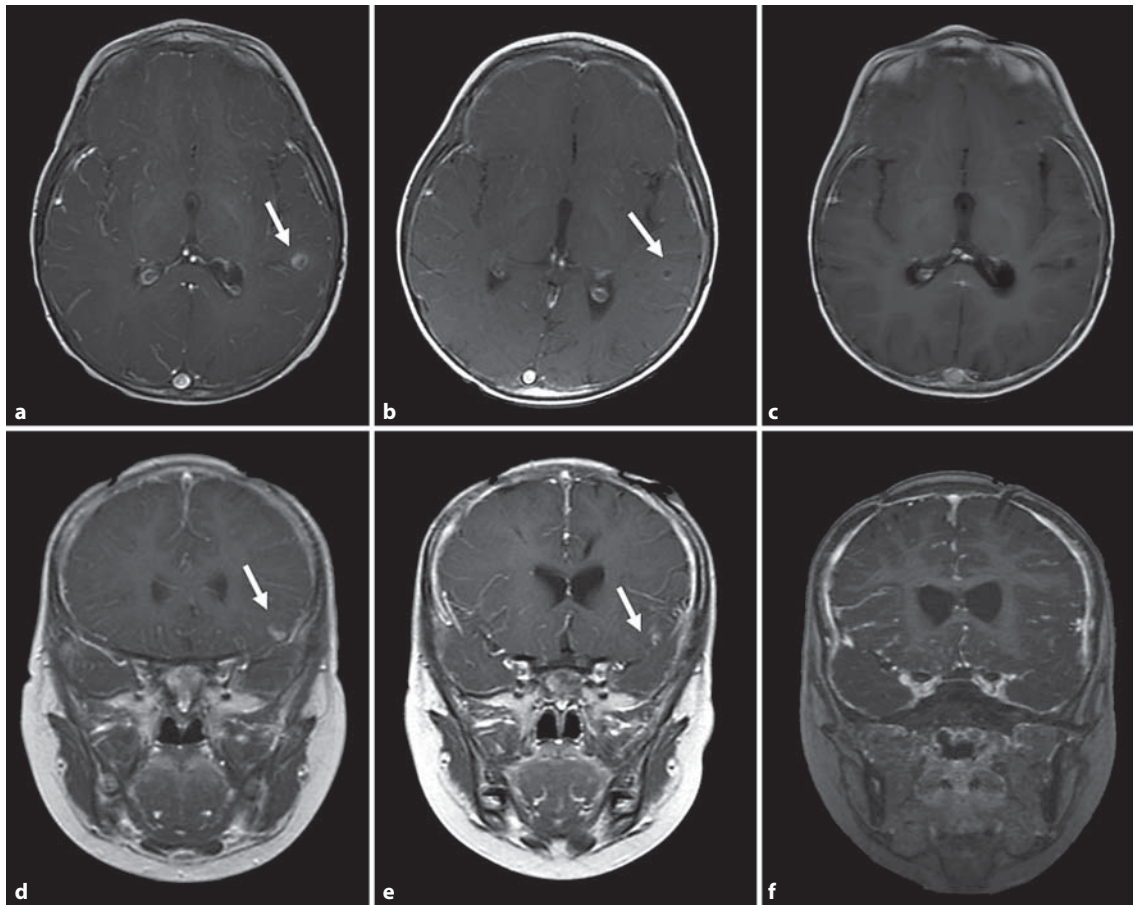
MRI of brain. a T₁-weighted axial diagnosis of RICH: the lesion was heterogeneous with a rim of peripheral T₂-weighted/FLAIR hyperintensity and central hypointensity suggestive of cavernous hemangioma. b Three-month therapy with bevacizumab shows decrease in size by 33%. c After 6 months of bevacizumab therapy complete resolution of RICH. d MRI of brain after T₁-weighted coronal sections with diagnosis of RICH. e Three months of therapy with bevacizumab. f Six months of bevacizumab therapy.
